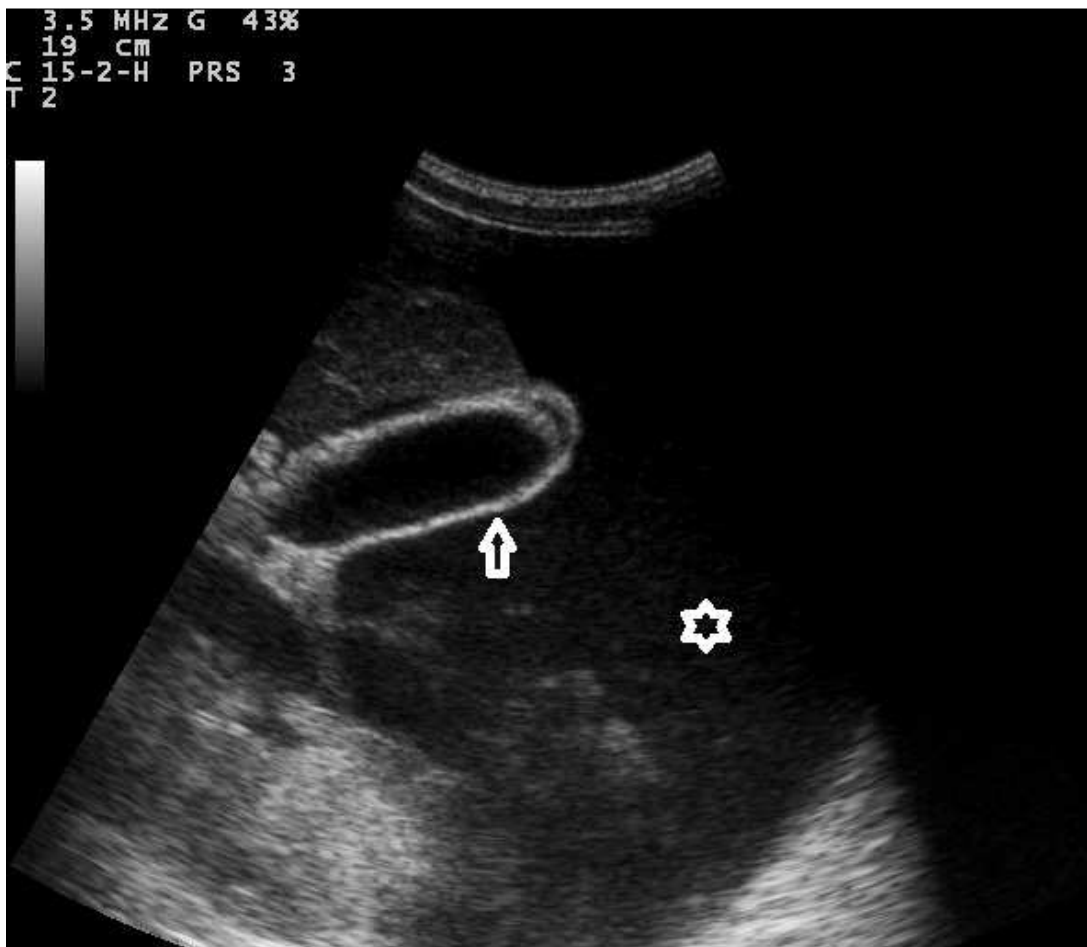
Abdominal ultrasonogram revealed (arrow) thin gall bladder wall (2 mm in a patients with malignant ascites (stellate) due to ovarian carcinoma.
